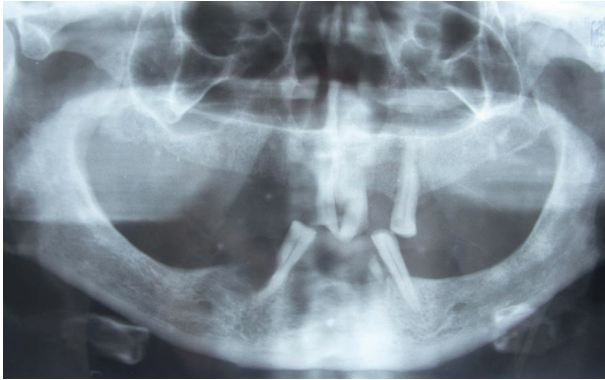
Radiolucent lesion and cortical defect in the anterior parasagittal aspect of mandible near right lateral incisor tooth (Panoramic mandible radiograph)
